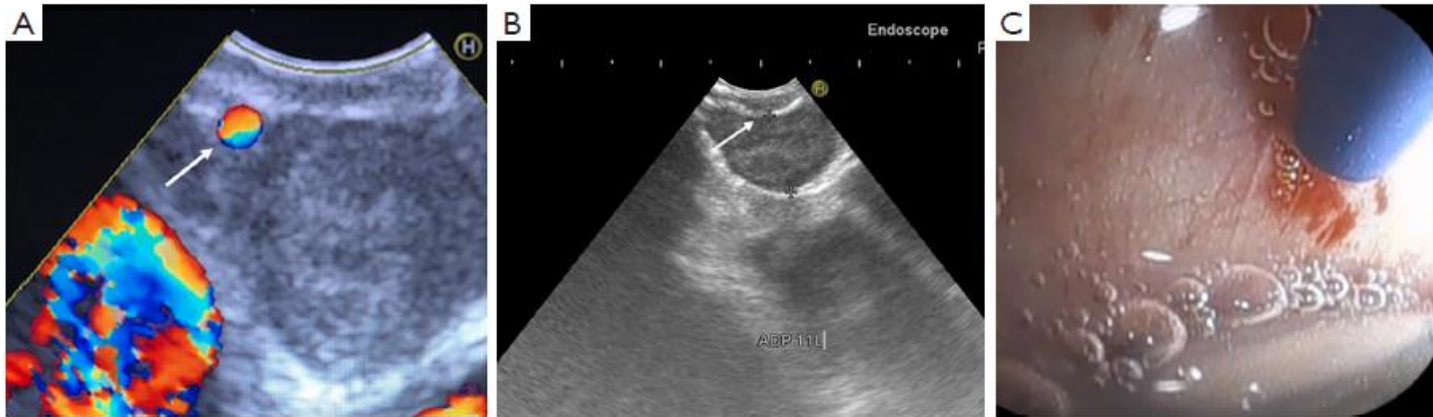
Lymph node stations and Doppler-mode on the ultrasound image. (A) Arrow showing a vessel in the proximal zone of the lymph node. (B) Arrow showing the location with the thinnest mucosa and lymph node capsule. (C) Needle sheath avoiding cartilage before performing the puncture. ADP, adenopathy.
